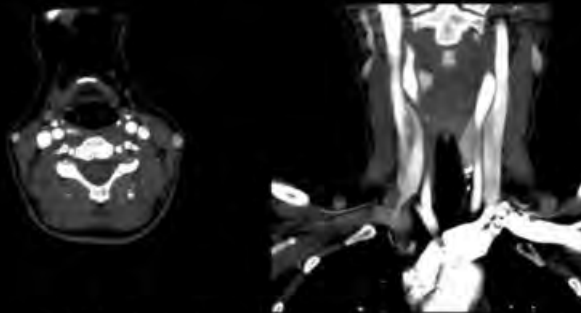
Axial and coronal CT images demonstrating anterior hypopharyngeal peripherally enhancing parathyroid adenoma.
